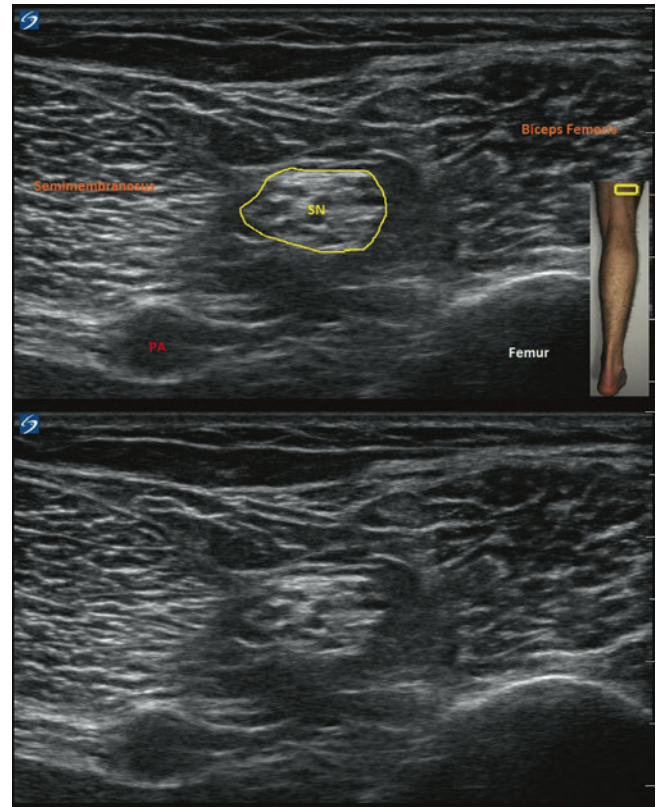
Ultrasound identification of the sciatic nerve in the posterior thigh, between the biceps femoris and the semimembranosus muscles. PA popliteal artery (popliteal vein is compressed, lateral to the popliteal artery), SN sciatic nerve (Image courtesy of Agnes Stogicza, MD)
